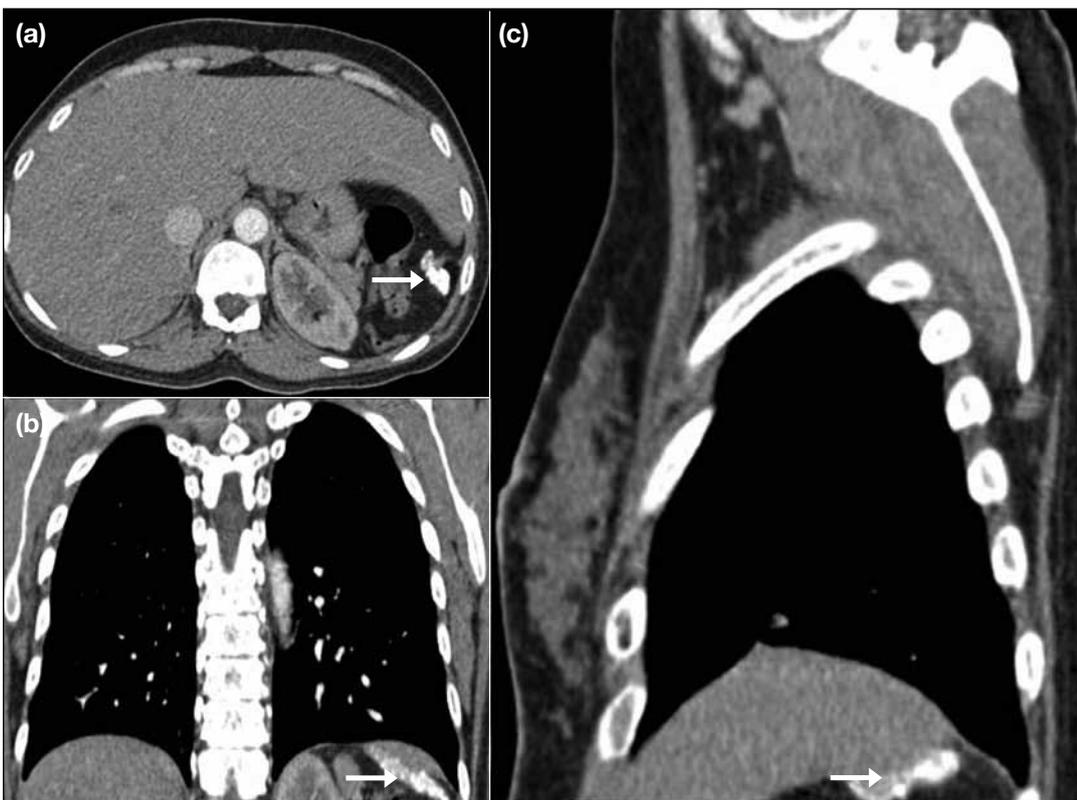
A 30-year-old female with sickle cell disease: (a) axial, (b) coronal, and (c) sagittal reformats of computed tomography showing an atrophied calcified spleen (arrows).
